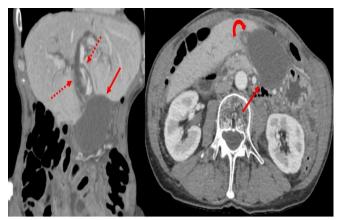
CT images of gallbladder torsion with dilated gallbladder located within the mid to left hemi-abdomen (solid arrow), diffuse intrahepatic biliary duct dilatation (dashed arrows), and enhancing cystic duct/vascular pedicle along the right margin of the gallbladder (curved arrow).
